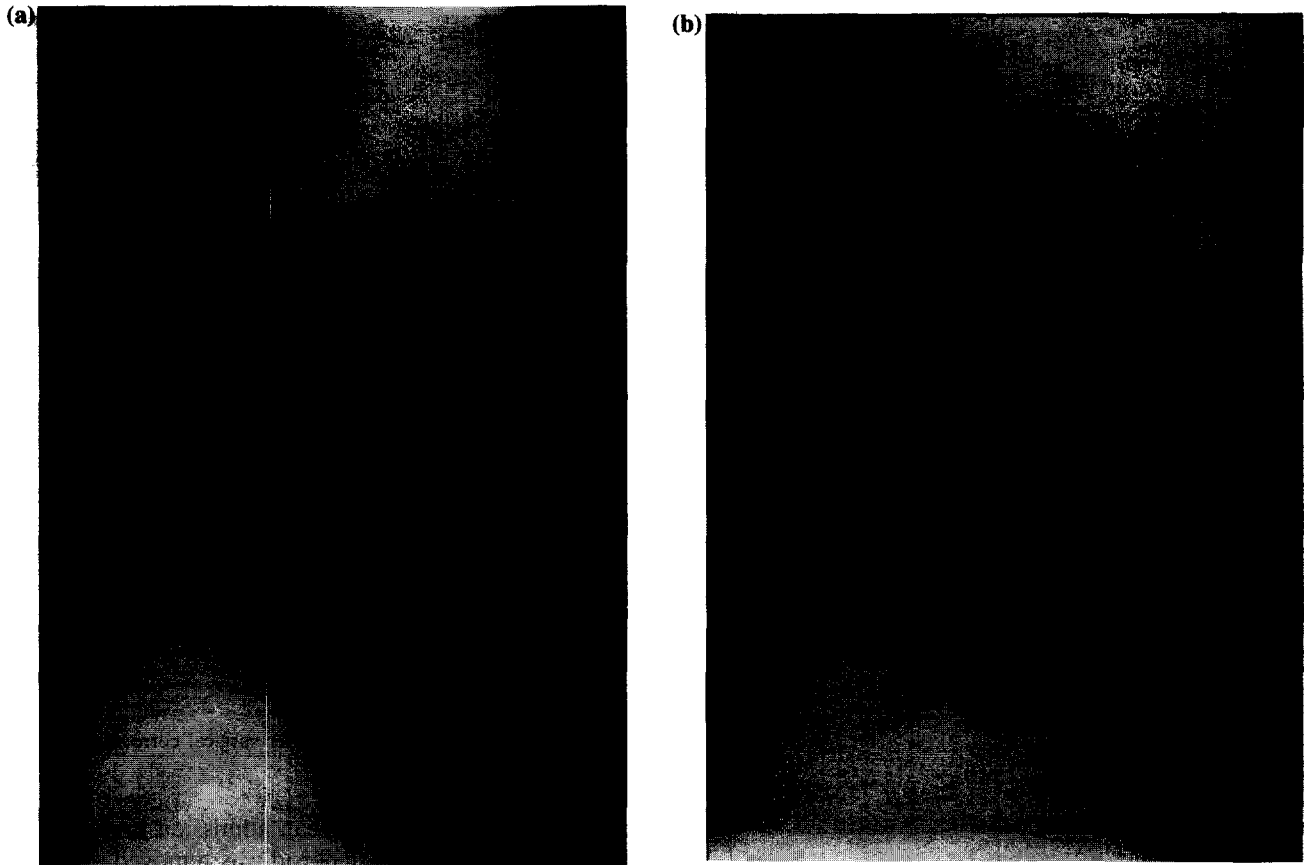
Chest X-ray (lateral view) of: (A) patient with pectus carinatum; (B) patient with pectus excavatum.
